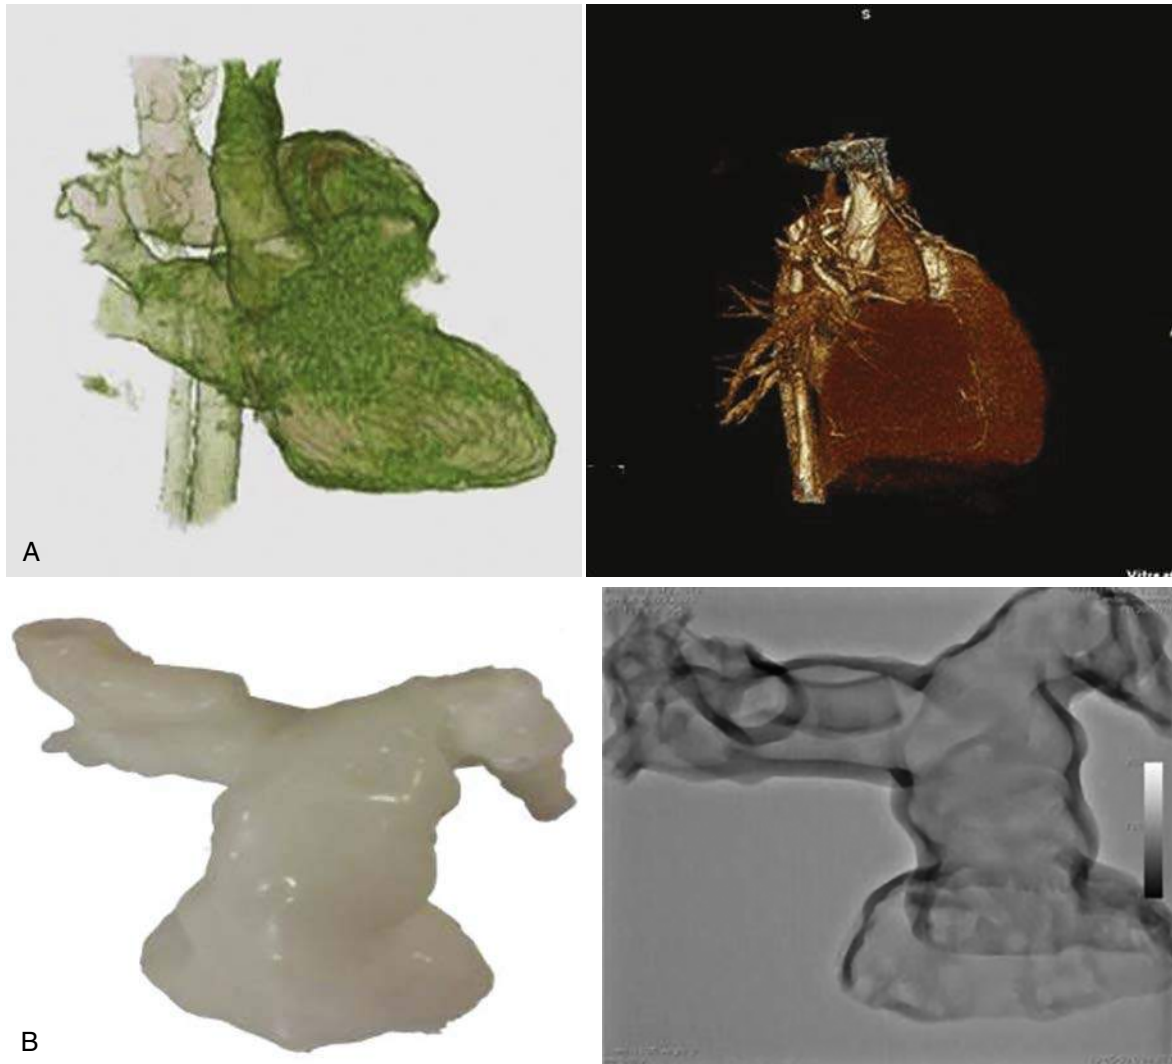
(A and B) Three-dimensional computed tomography (3D CT) reconstruction of patient's right ventricular outflow tract/pulmonary artery (RVOT/PA) used to create a silicone-based model. Patient suitability for performing alignment maneuver tested in laboratory and found to be feasible for retrograde transcatheter pulmonary valve delivery from an right internal jugular approach.
